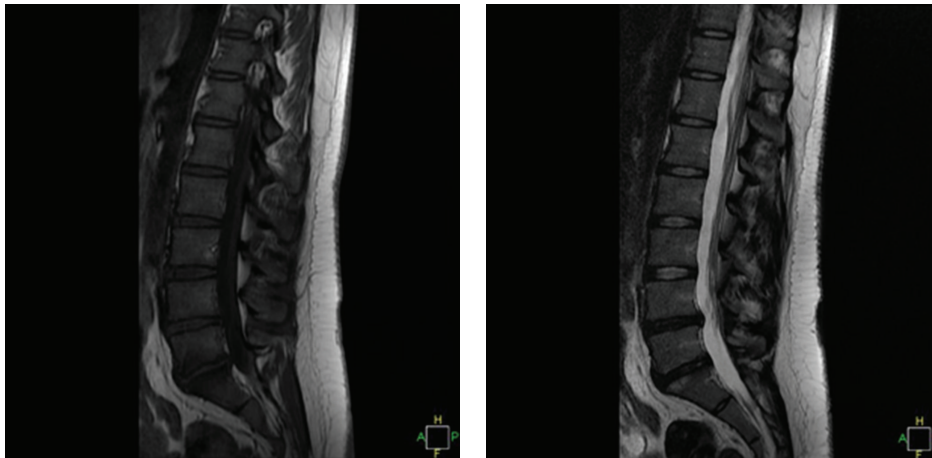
This MRI has two levels of decreased disc signal: L4-5 and L5-S1. There are early reactive endplate changes at L5-S1 as well (Modic type 1).
